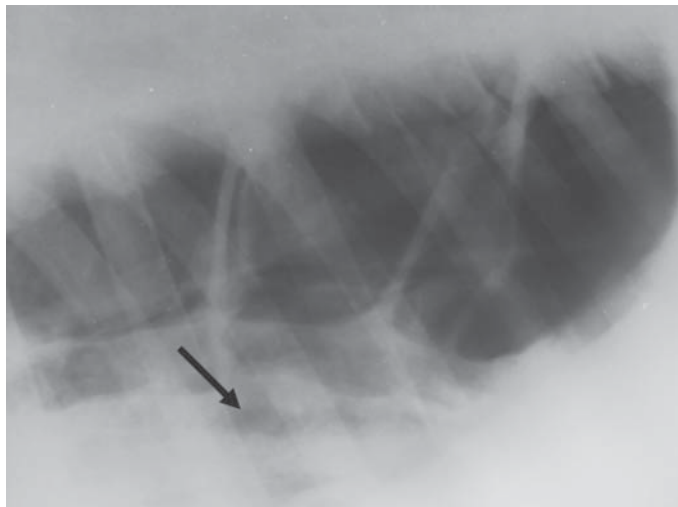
Radiographic view of the thorax - presence of organs filled with liquid
